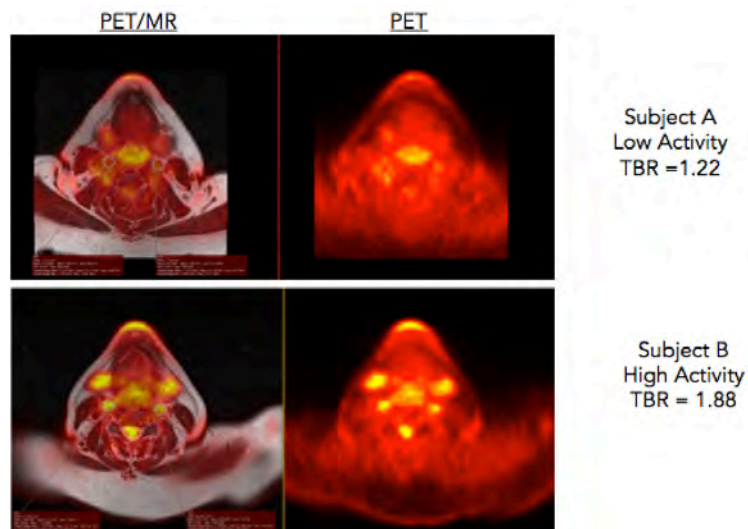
Hybrid PET/MR pictures of axial slices of the neck from two posttraumatic stress disorder (PTSD) subjects (Subjects A and B). Right side: ^{18}F -FDG PET scans showing metabolic activity and inflammation in carotid arteries. Left side: ^{18}F -FDG PET scans registered onto MRI scan acquired simultaneously to PET. MRI provides anatomical and resolution. Subject B visibly and quantitatively has more inflammation in carotid arteries.
